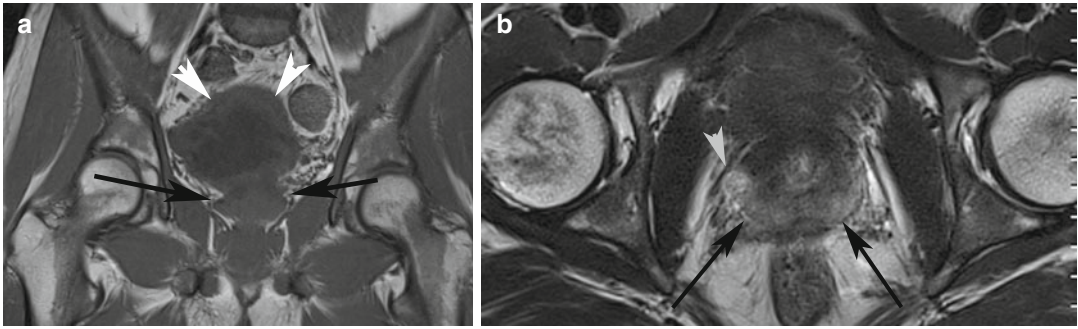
Twenty-nine-year-old man with neurogenic bladder and chronic prostatitis (same patient as in Fig. 17.12). (a) Coronal T1-W MR image shows normal low signal intensity in the prostate (*black arrows*) indicating lack of hemorrhage in the tissue (patient had not undergone a biopsy). Diffuse bladder wall thickening
